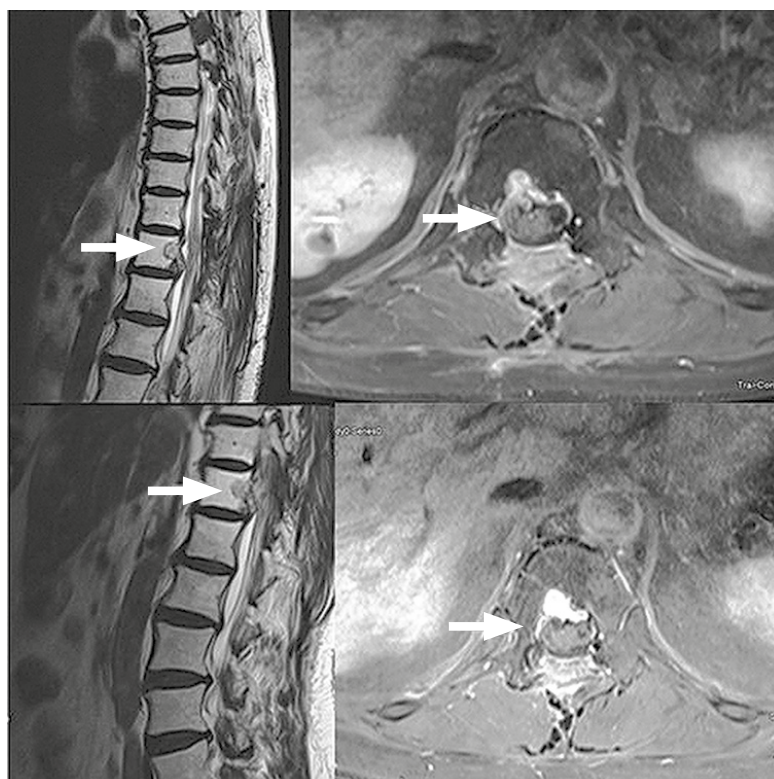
MRI of the spine, T1 mode. The top photo is 5 months after stereotactic radiation therapy (stabilization). The lower photo is 13 months after stereotactic radiation therapy, T1 mode (stabilization).
